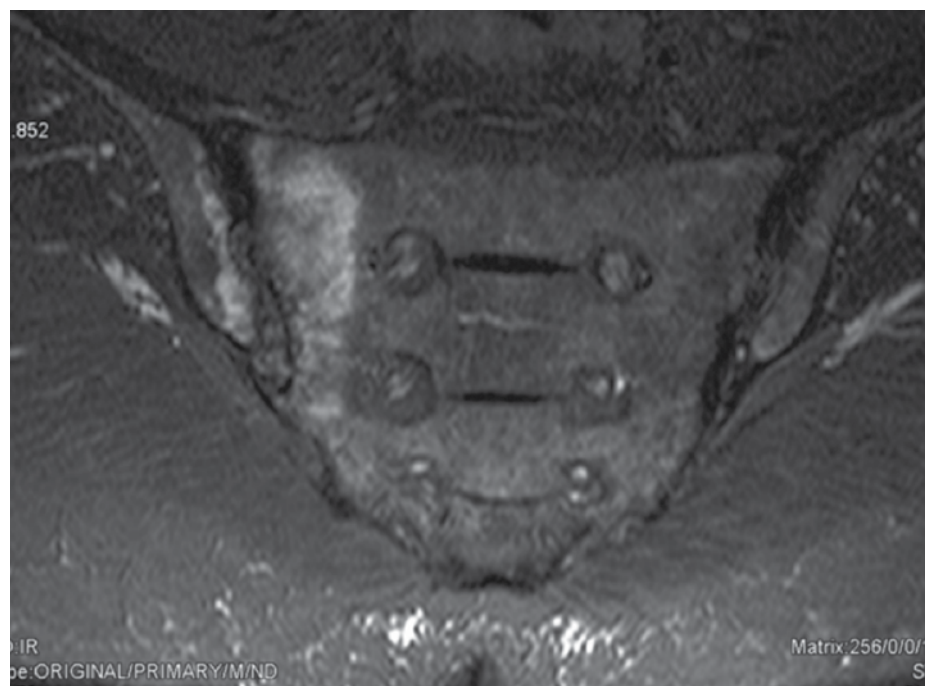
Coronal STIR MR image shows bilateral active sacroiliitis, more prominent on the right side (there is extensive bone marrow edema both sides of the right sacroiliac joint)
